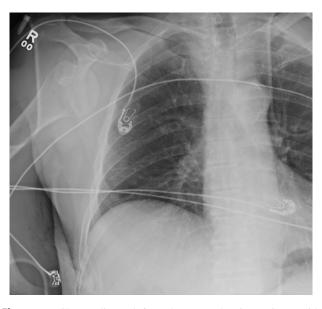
Chest radiograph from the trauma bay is consistent with a shoulder dislocation of the glenohumeral joint.
